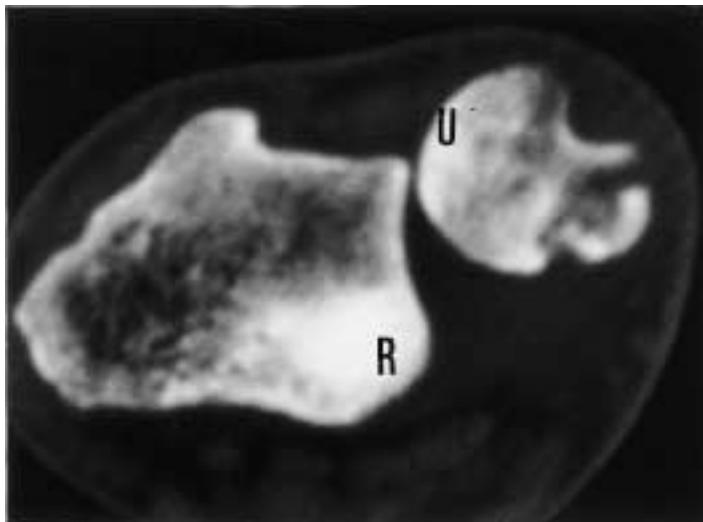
Computed tomography of the distal radioulnar joint in a patient with dorsal subluxation (R: radius, U: ulna).
